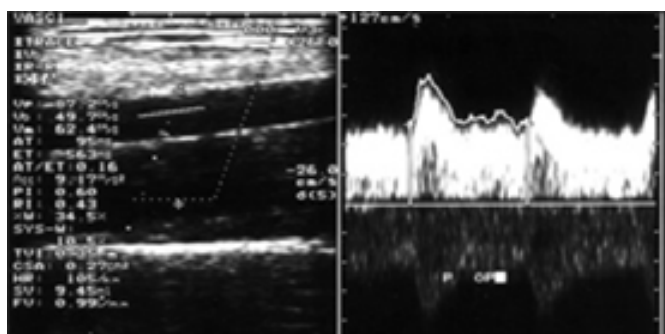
A 65-year old woman with an antecubital arteriovenous shunt: A Doppler spectrum was obtained in a longitudinal plane of feeding artery of the shunt with an appropriate insonating angle of 63° and the entire luminal cross section was included in the sample size. Flow volume of the shunt is 990 mL/min.
